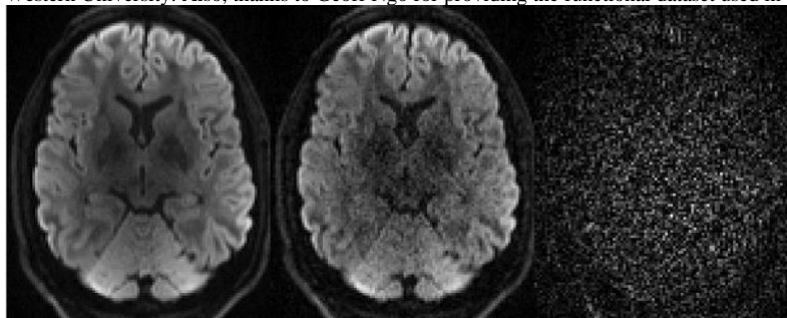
Qualitative comparison from diffusion MRI dataset. Left: reconstruction (\hat{x}); Middle: fully sampled image (x); Right: $5 \times |\hat{x} - x|$.
